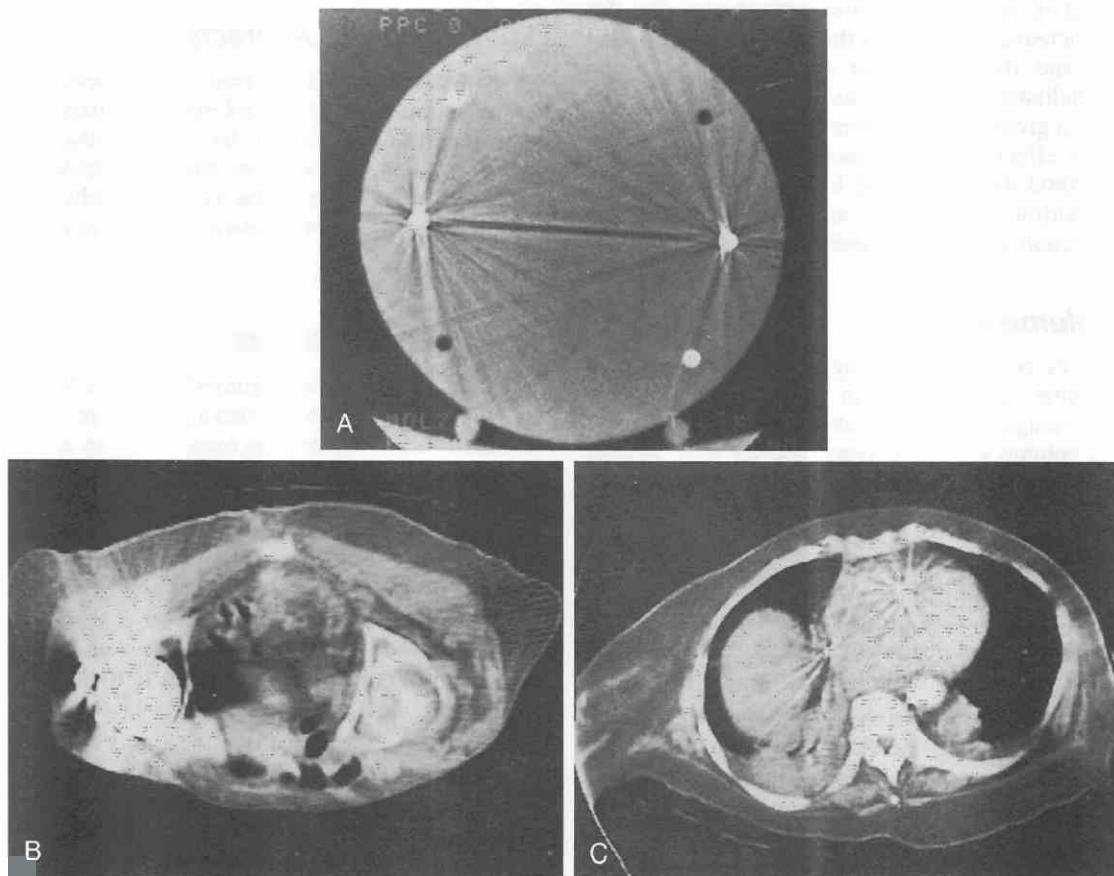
Streak artifacts. *A*, Uniform media with metallic pin; note the large amount of streak artifact. *B*, A hip prosthesis. *C*, Starburst streaks from clips in the pulsating heart of conventional (single-ring) CT scanner.
